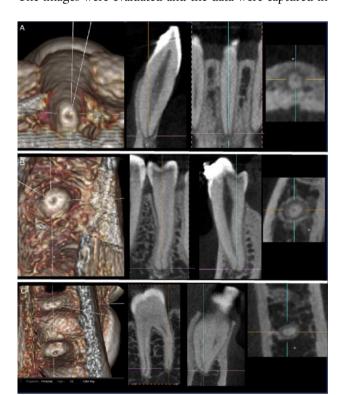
Determination of apical foramen position using multiplanar cone beam computed tomography. Axial, sagittal, coronal, and 3D sections.
